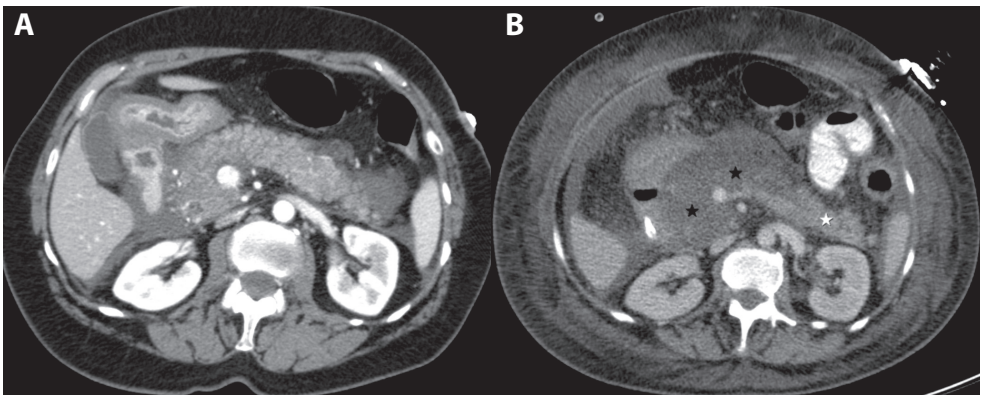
A 47-year-old woman with false negative parenchymal necrosis on early CT. (A) Contrast-enhanced CT on day 1 shows a heterogeneous enhancing pancreatic parenchyma, but no apparent areas of nonenhancement. (B) Repeat CT was performed on day 4 showing clear nonenhancement of pancreatic head, neck and part of body (black stars), while the tail shows preserved enhancement (white star).
